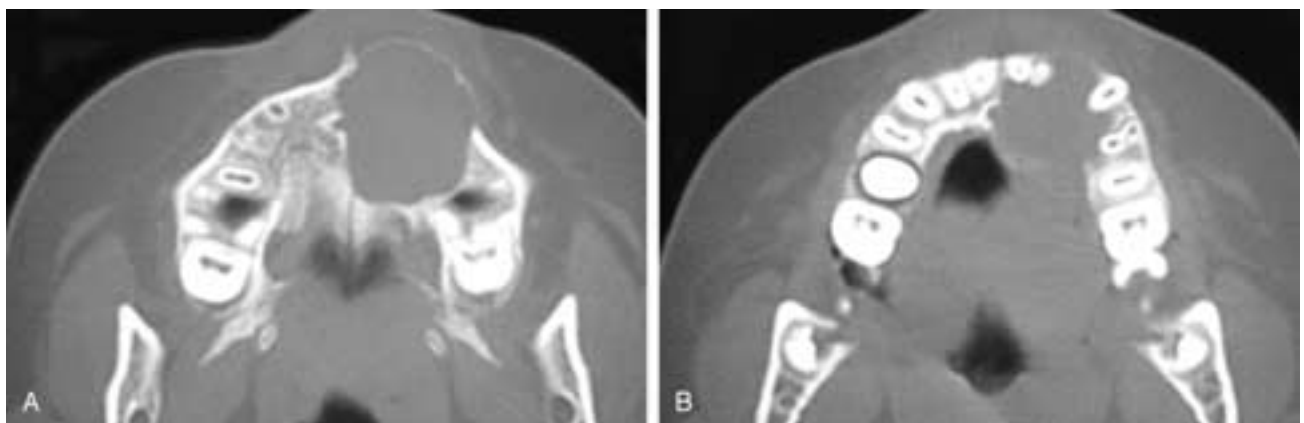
Axial CT scans (A and B) show an expansile cystic mass in the left alveolus and hard palate. The cyst wall is seen in relationship to the left lateral incisor tooth. This patient had a radicular cyst.
